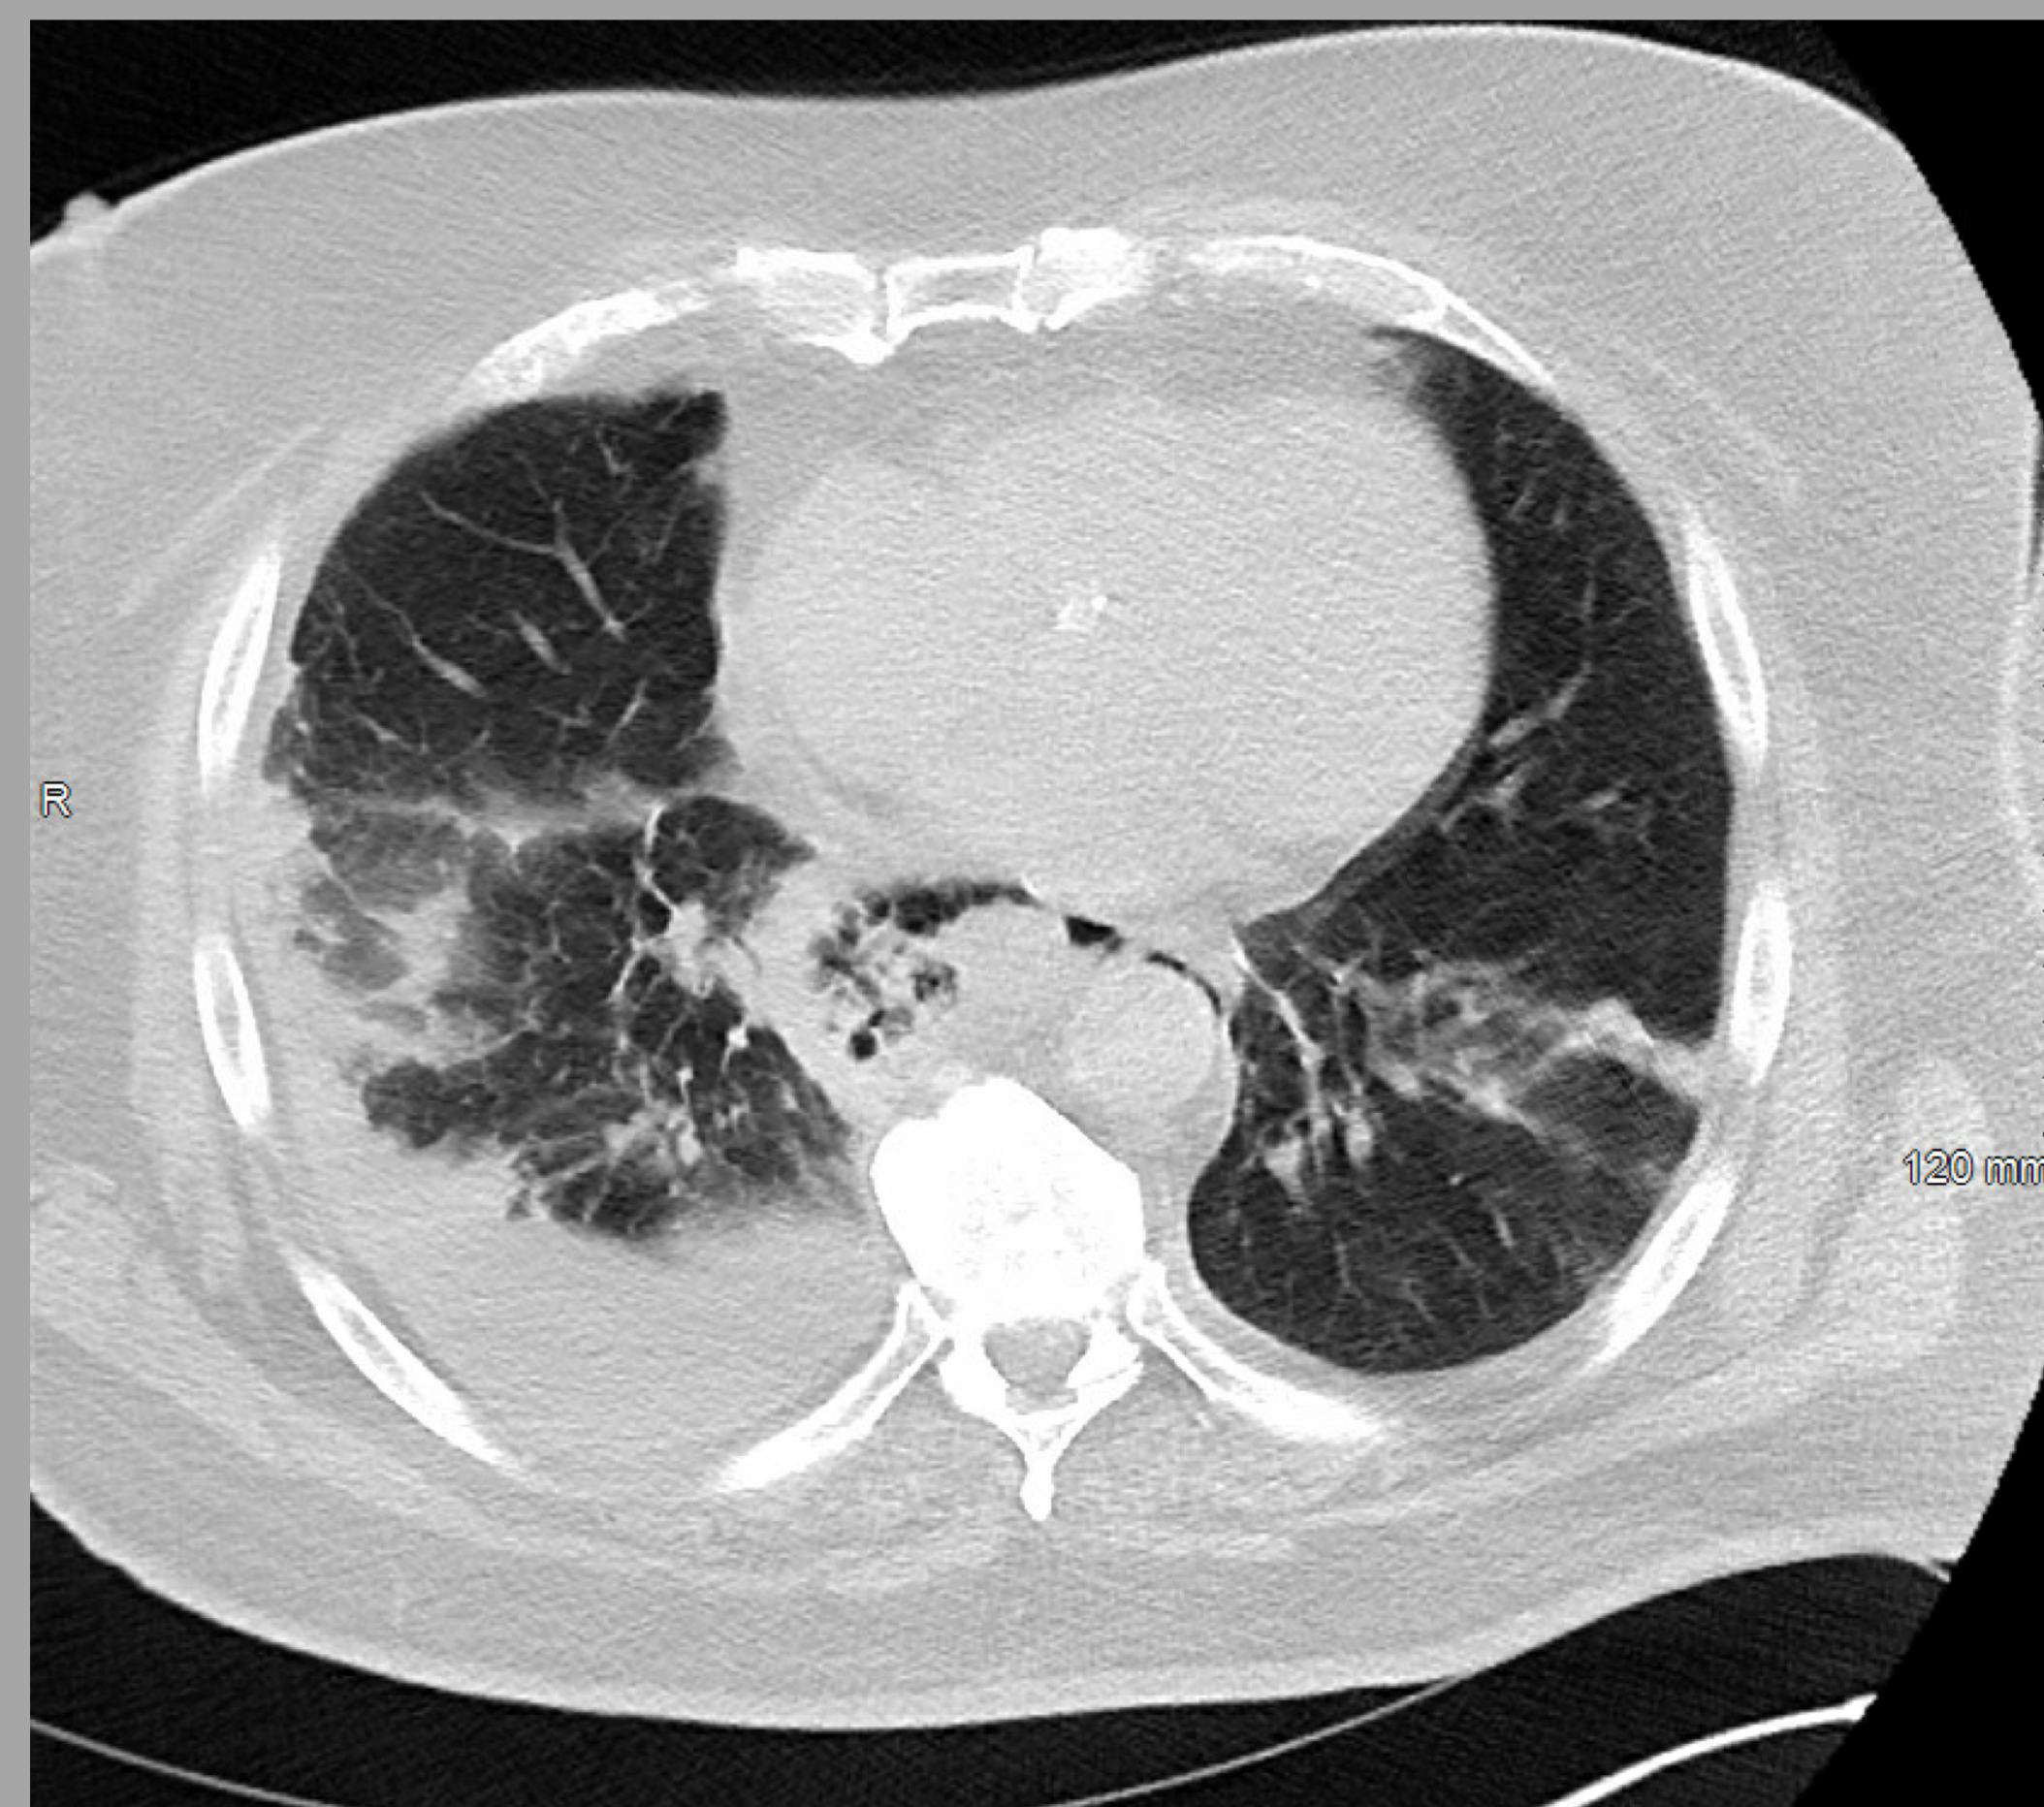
Transverse slice of CT chest demonstrating esophageal perforation with right sided pleural effusion
